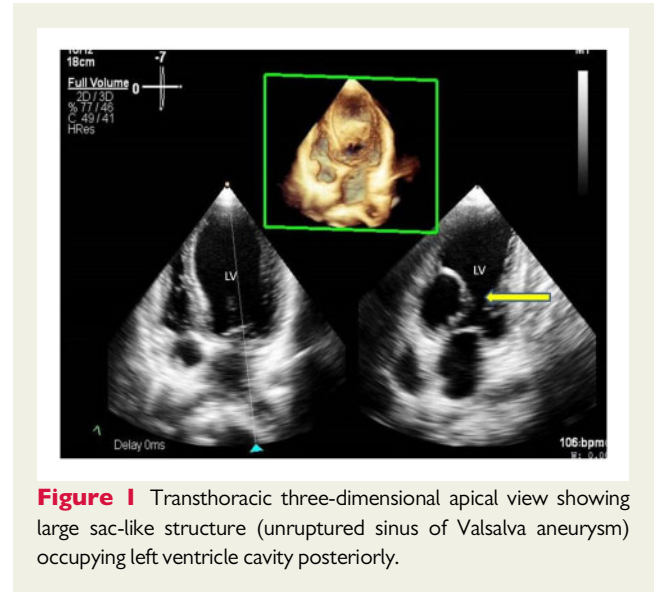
Transthoracic three-dimensional apical view showing large sac-like structure (unruptured sinus of Valsalva aneurysm) occupying left ventricle cavity posteriorly.
